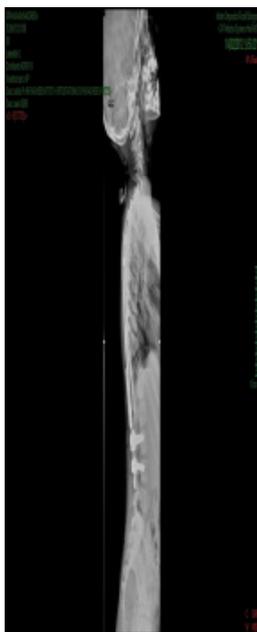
Postoperative x-rays after initial surgery (Case 2).
